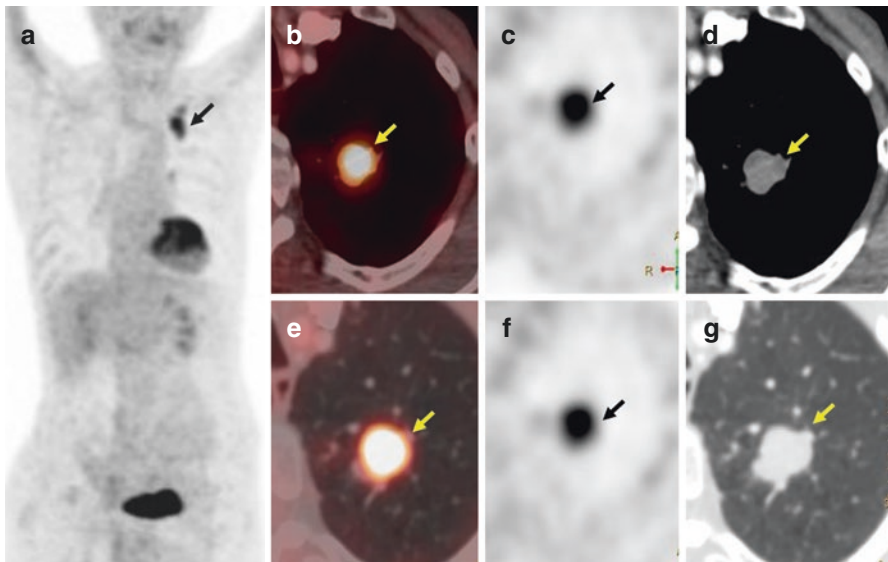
FDG PET/CT MIP (a) and axial (b–g) images show intensely FDG-avid nodule in the left upper lobe (arrow). Biopsy showed epithelioid granulomas with fibrosis. Patient responded to antituberculous treatment
